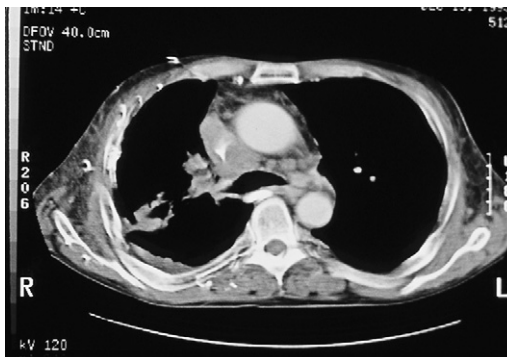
CT scan demonstrating SVC compression.
